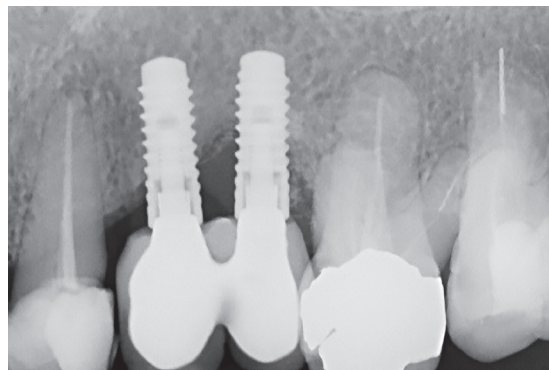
Dental X-ray follow-up after 24 months, presenting an image compatibly with a bone regeneration around of the implant.
